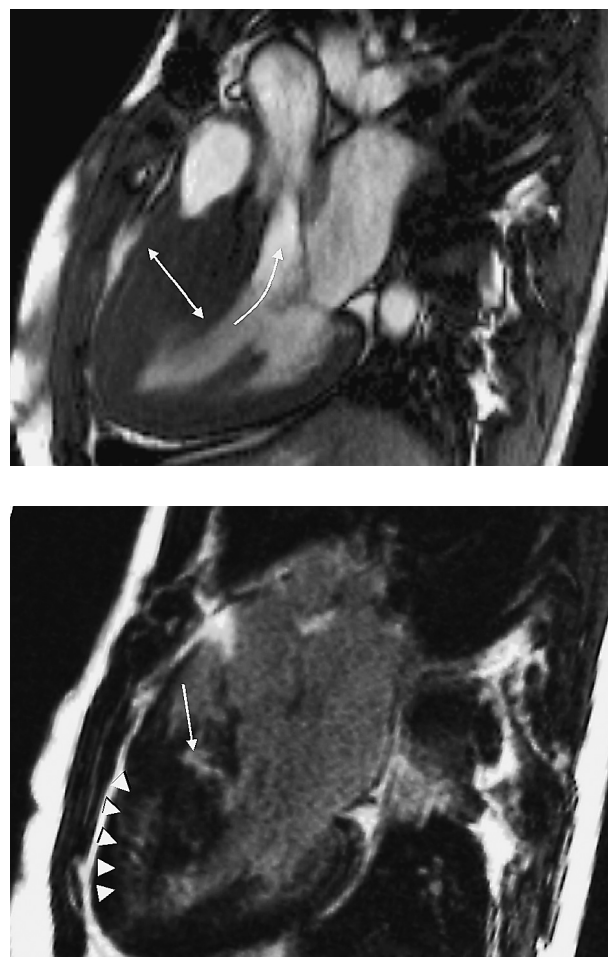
Cardiac MRI was performed six months after septal ablation: (a) systolic still image of a balanced gradient echo cine in LVOT view, showing the hugely thickened IVS (double-headed arrow) and the stenotic jet it produces (curved arrow). (b) Late gadolinium enhancement in the same orientation, showing the post-ablation scarring in the LVOT segment (arrow), and extended fibrosis in the middle and anterior part of the IVS (arrowheads). A residual gradient of 20 mmHg is measured (not shown).
